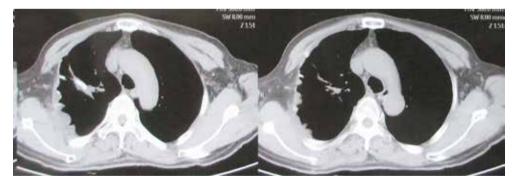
Post-operative CT scan. Computed tomography (CT) showed that the large mass was already resected and the chest wall was reconstructed using synthetic material.
